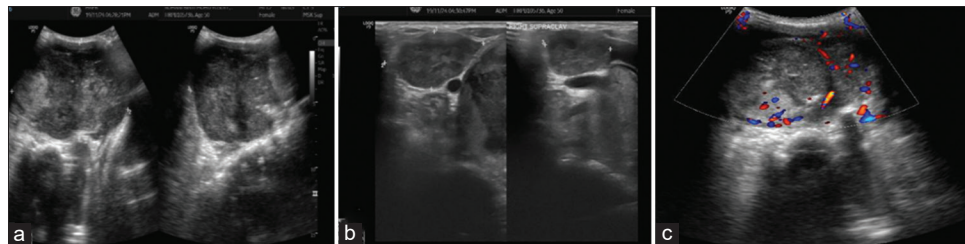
Pre-operative ultrasonography of the patient (a and b), color Doppler imaging of the tumor (c)
